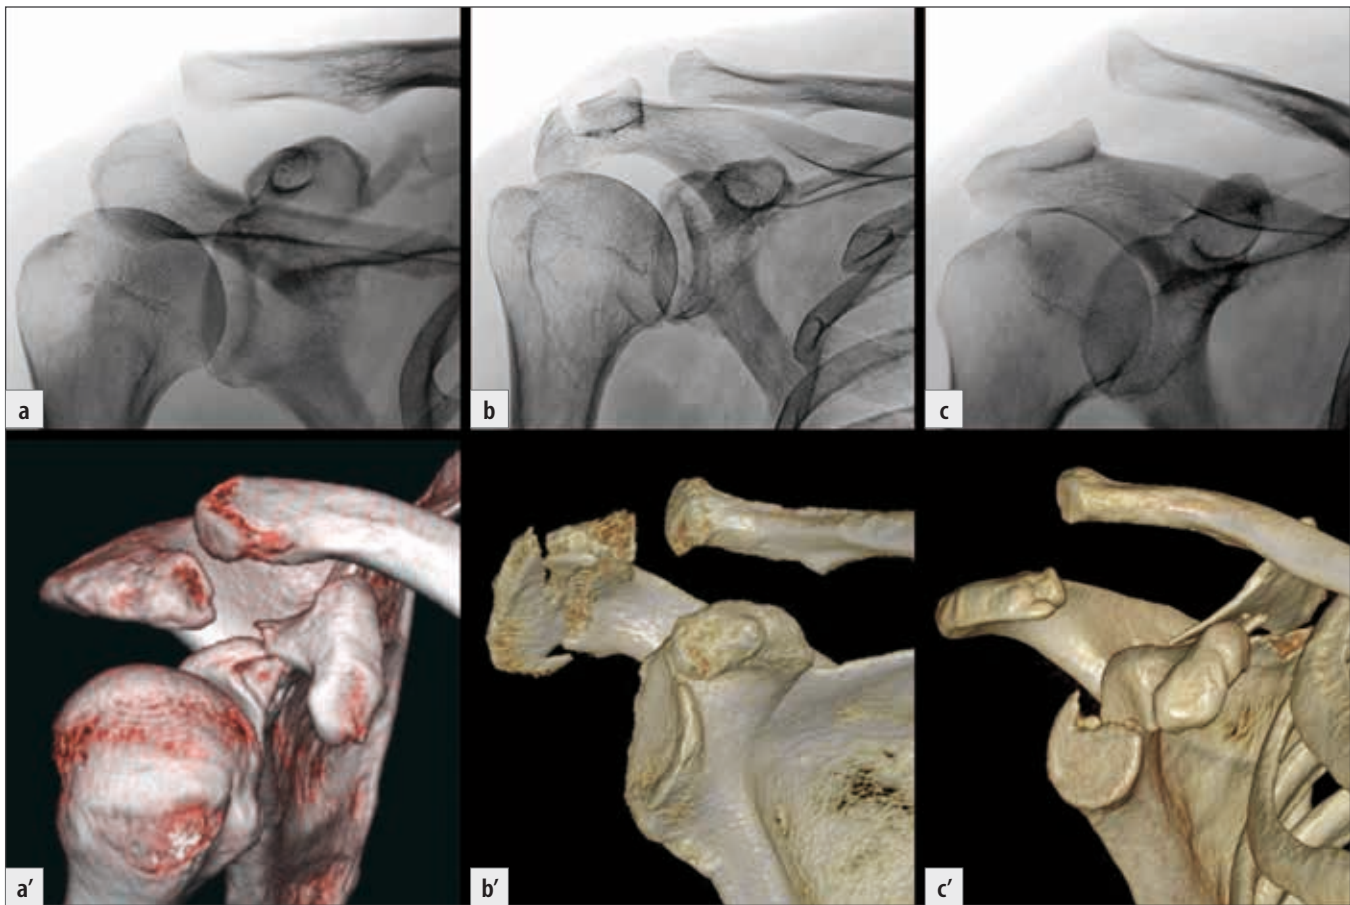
AC dislocation types on radiographs and 3D CT reconstructions: a) type III; b) type IV; c) type V.
